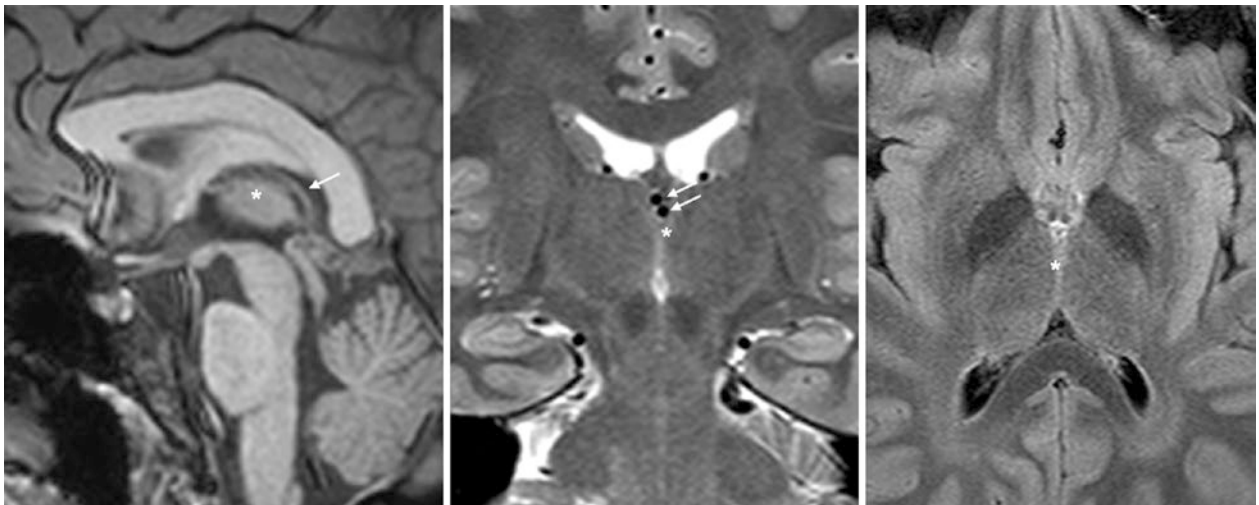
A 27 year old who had a 3T MRI performed for headaches, which showed a pseudomass of the massa intermedia (*) on a midline sagittal T1WI (left). Coronal T2WI (middle) and axial FLAIR (right) did not confirm a mass and depicted the thin connection between the thalami. Note the internal cerebral veins (arrows) behind the massa intermedia
